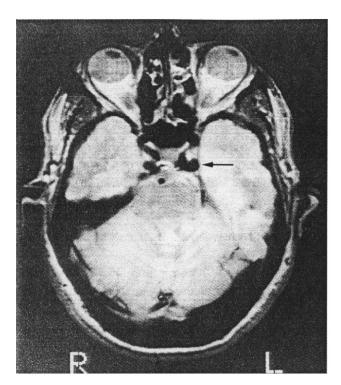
Axial proton density-weighted magnetic resonance imaging through the cavernous sinuses demonstrates a lateral tortuous ectasia of the posterior portion of the left internal carotid artery (arrow).
